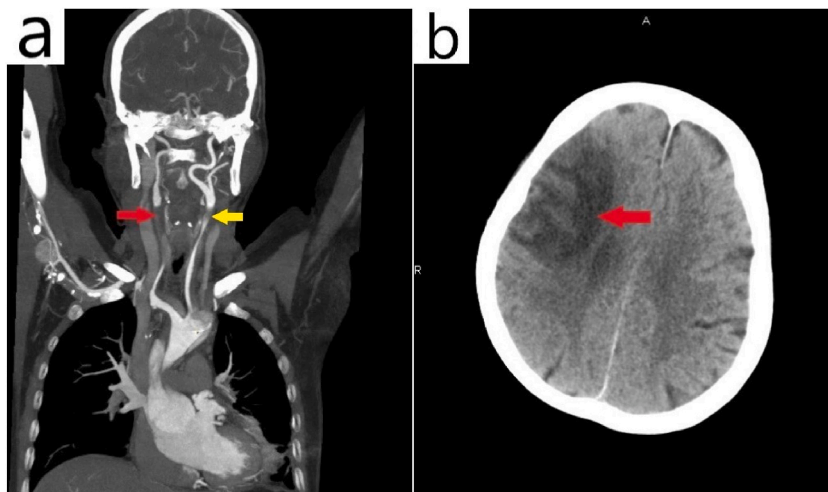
A 61-year-old woman presented with thoracic and back pain for 10 h and no neurological symptoms before admission. Aortic CTA showed ATAAD with occlusion of right CCA (red arrow) and severe true lumen stenosis of left CCA (yellow arrow) (a). Brain CT on the fifth day after the emergency surgery showed an infarct in the right parietal lobe (b, red arrow). CTA = computed tomography angiography, ATAAD = acute type A aortic dissection, CCA = common carotid artery.
